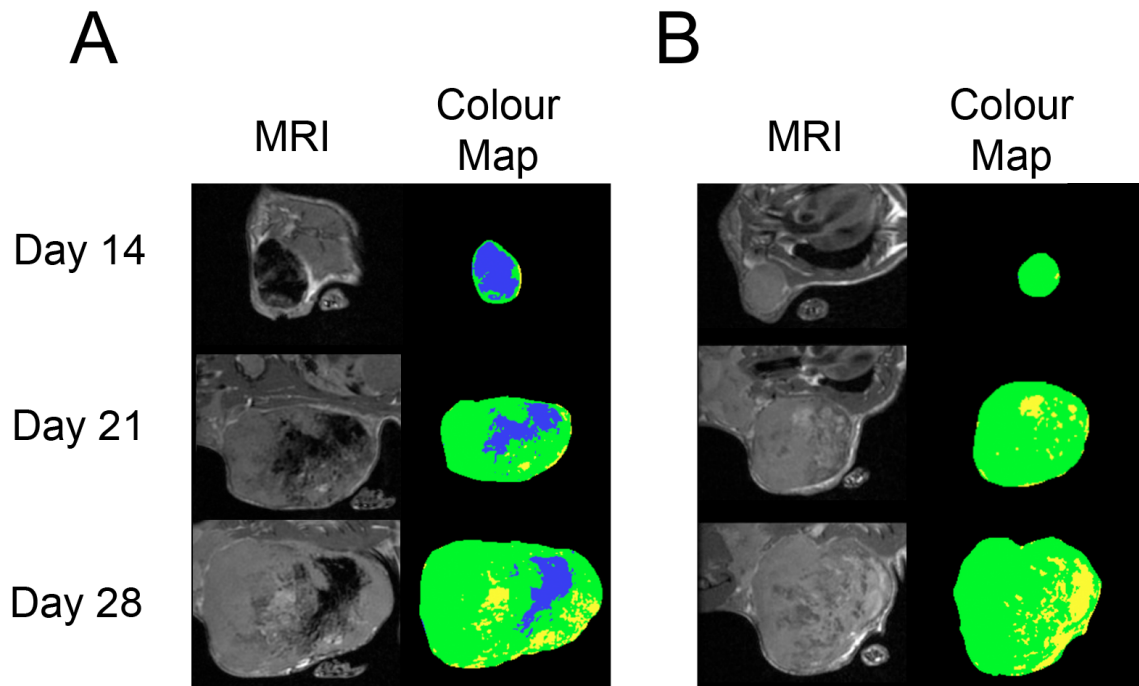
Appearance of labeled and unlabeled tumors over time and corresponding tumor color maps. (A) The MR image and color map, respectively, of a labeled tumor
